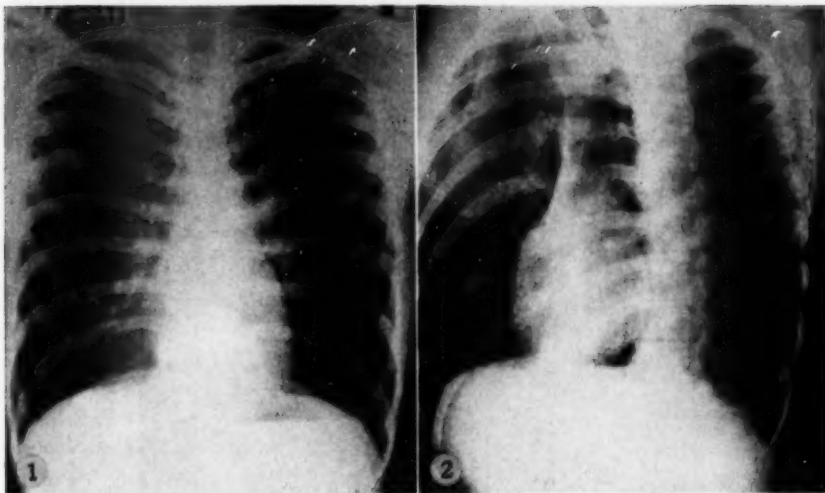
X-ray of the chest, posteroanterior view, showing the discrete solitary nodule in the lower portion of the right lung.
